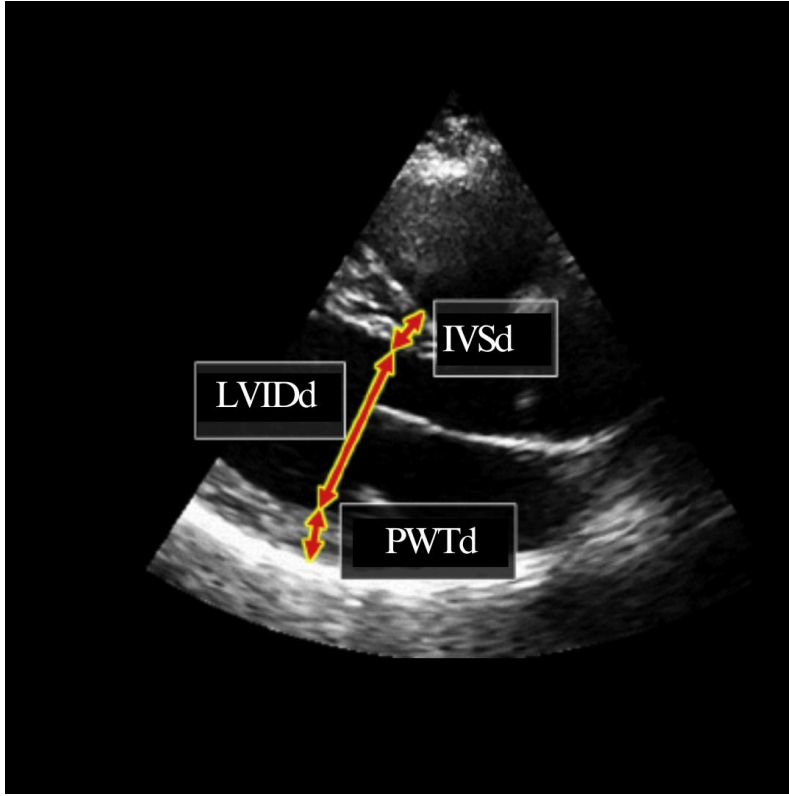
Example of echocardiographic measurements (adapted from Perperidis, 2015)
